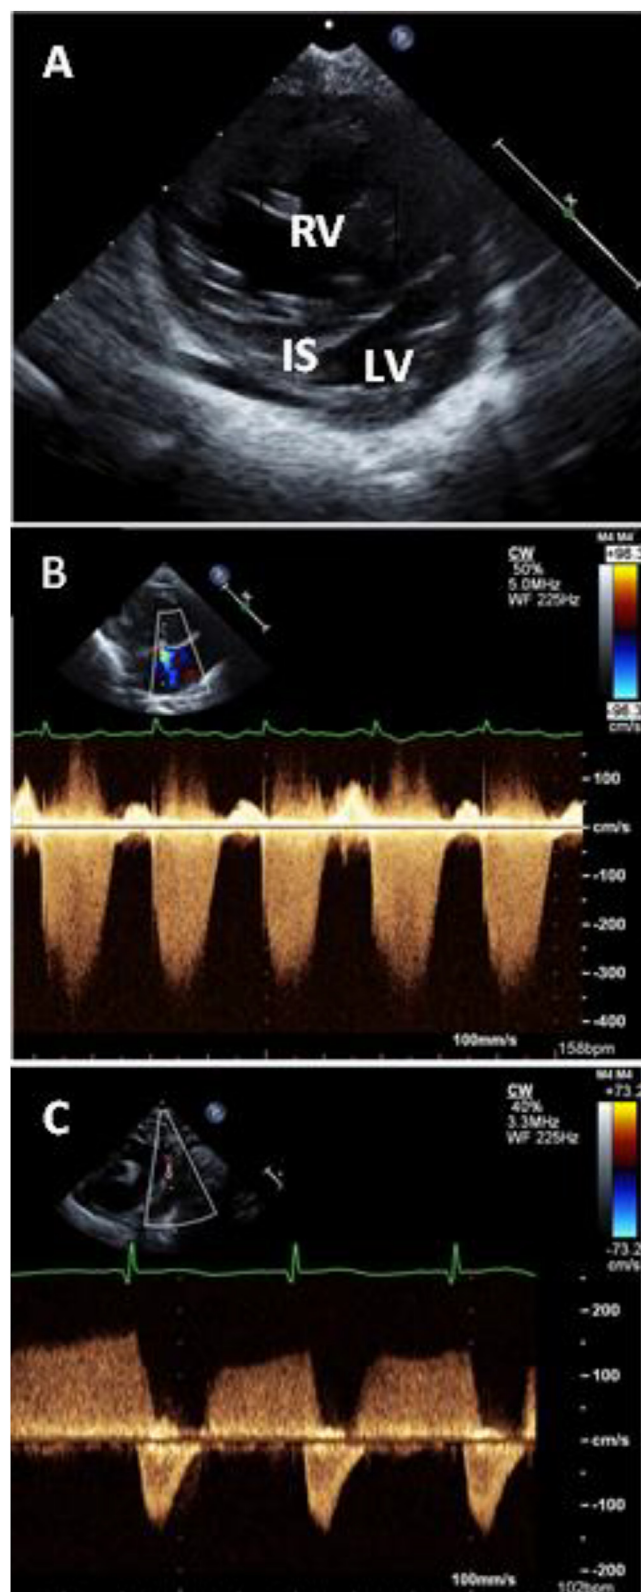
Echocardiographic images of pulmonary hypertension. A. Parasternal short axis view demonstrating dilated right ventricle (RV) and flattened interventricular septum into the left ventricle, consistent with severe pulmonary hypertension. B. Tricuspid regurgitation Doppler demonstrating peak regurgitant velocity. C. Bidirectional flow across the PDA with flow below the baseline demonstrating right to left flow during systole, consistent with elevated pulmonary pressures. RA = right atrium, RV = right ventricle, IS = interventricular septum, LV = left ventricle.
